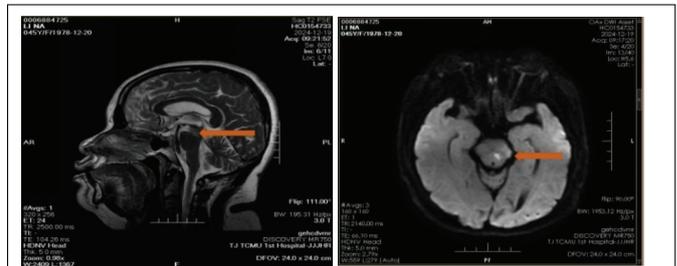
MRI shows lesion was located on the ventral side of the mid-brain.
